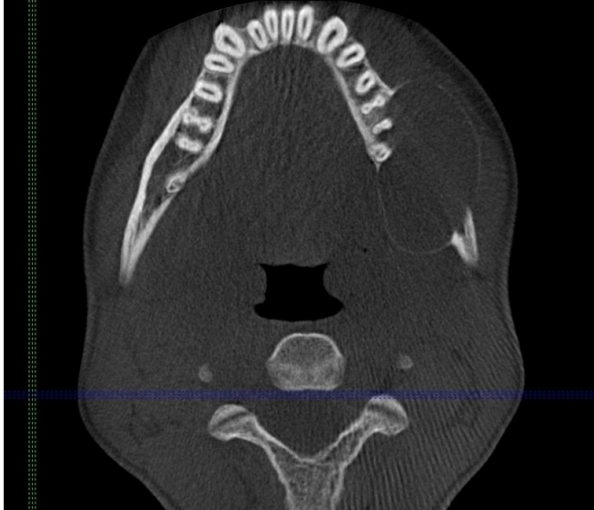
Axial section of a helical CT scan showing a unilocular lesion, without septa or locules, with well-defined peripheral borders, affecting the left mandibular region, with expansion of the lingual and buccal cortices. The lesion is observed in close contact with teeth 37 and 36.
